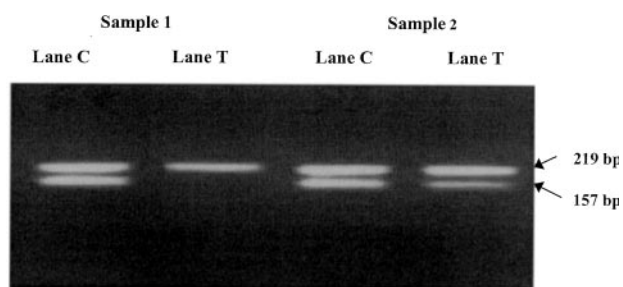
Genotyping of polymorphism $169 C \rightarrow T$. The figure shows two DNA fragments of 219 bp and 157 bp that correspond to the products from internal amplification control primers and allele-specific primers, respectively. *Sample 1*, homozygote *CC*; *Sample 2*, heterozygote *CT*.
